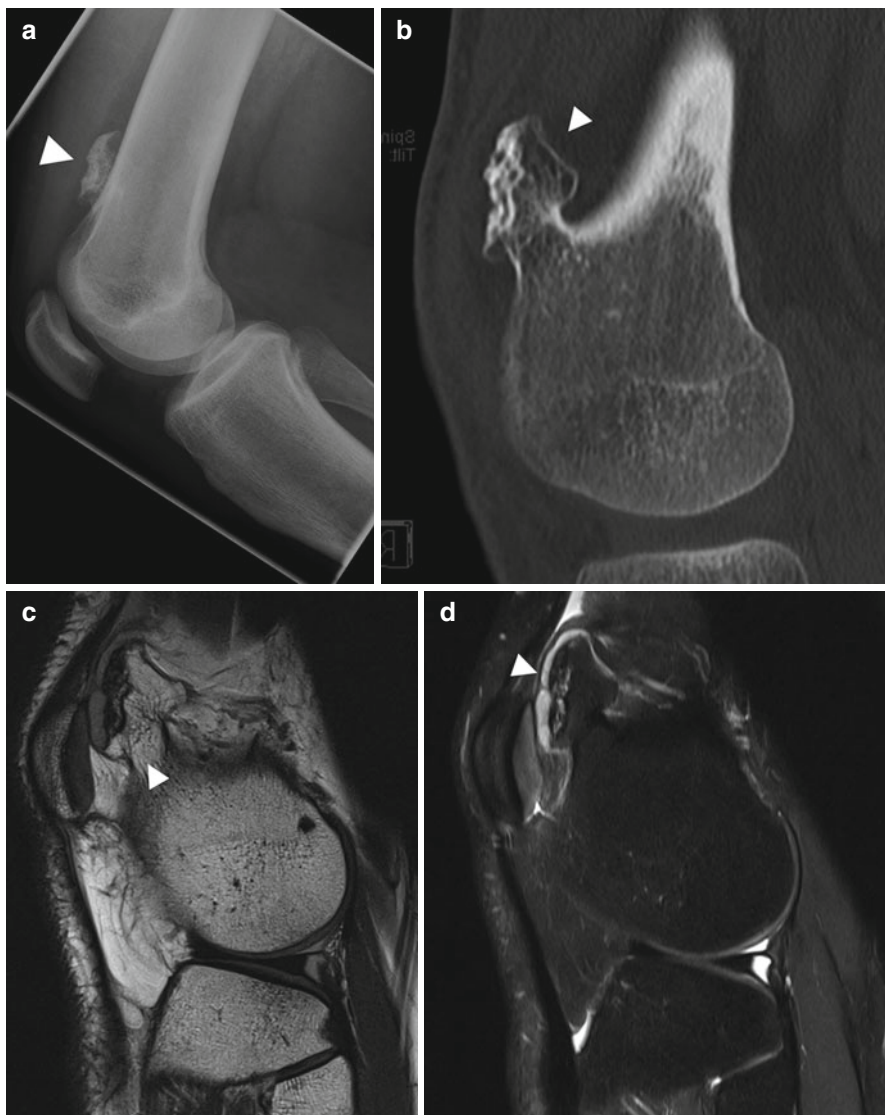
Diagnostic workup. Same subject as Fig. 10.5. Conventional radiograph (a) shows a sessile osteochondroma (*arrowhead*) extending from the cortex of the distal femoral metaphysis. CT scan (b) demonstrates the cortical and medullary portions of the lesion to be continuous with the parent bone (*arrowhead*). On MRI, the thickness of the cartilage cap – an important criterion of malignancy – can be measured. The cap (*arrowhead*) has intermediate signal intensity on sagittal PD image (c) and high signal intensity on sagittal fat-suppressed T2w image (SPAIR) (d)
